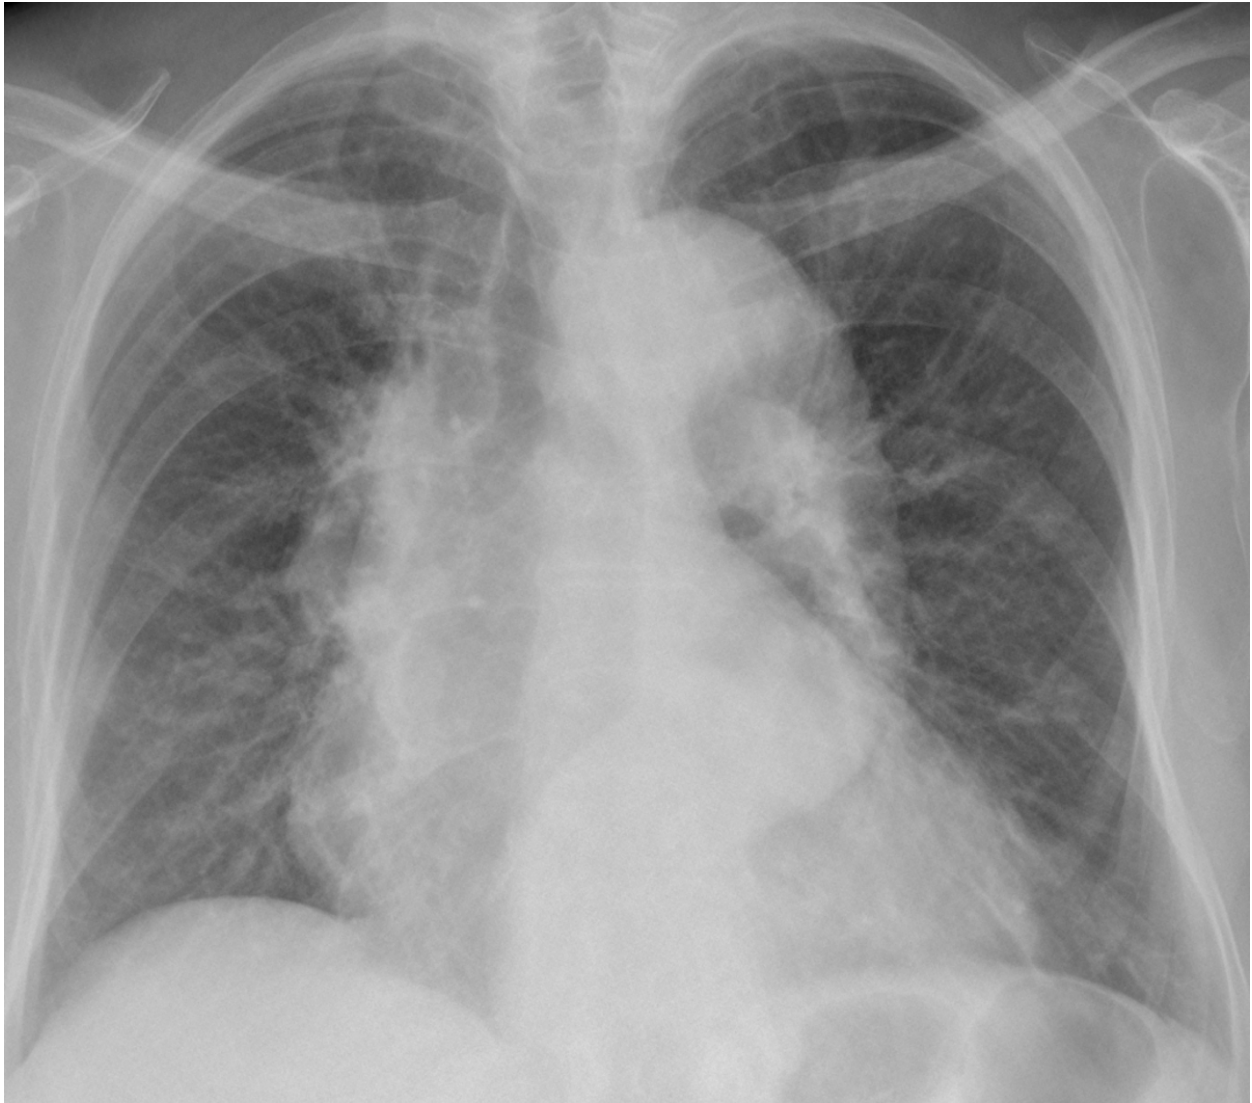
Frontal chest radiograph displaying the aortopulmonary window (white arrow), between the aortic and pulmonary arches.
